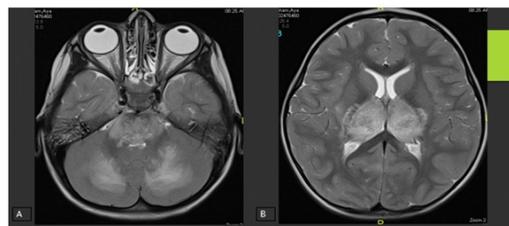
Axial T2 WI MRI of the brain at the level of pons (A), Basal Ganglia and Thalami (B), Showing swelling and bright T2 signal intensity with attenuated 3rd ventricle and basal cisterns.
